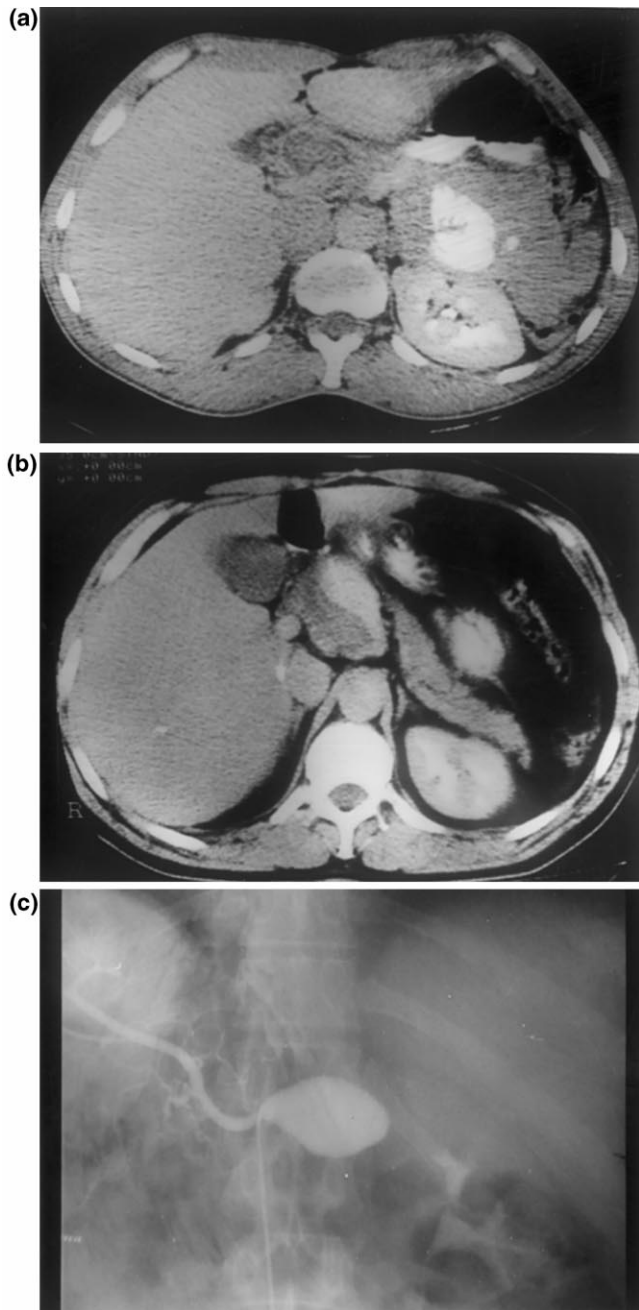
(a) CT scan study after acute attack of a patient with chronic pancreatitis shows hypodense area located at the pancreatic head. (b) Two years after the onset of the earlier attack, CT demonstrates the partially thrombosed hepatic artery pseudoaneurysm located above and causing downward displacement of the pancreatic head. (c) Superselective angiograms clearly demonstrating the non-thrombosed lumen of the aneurysm at the origin of hepatic artery.
